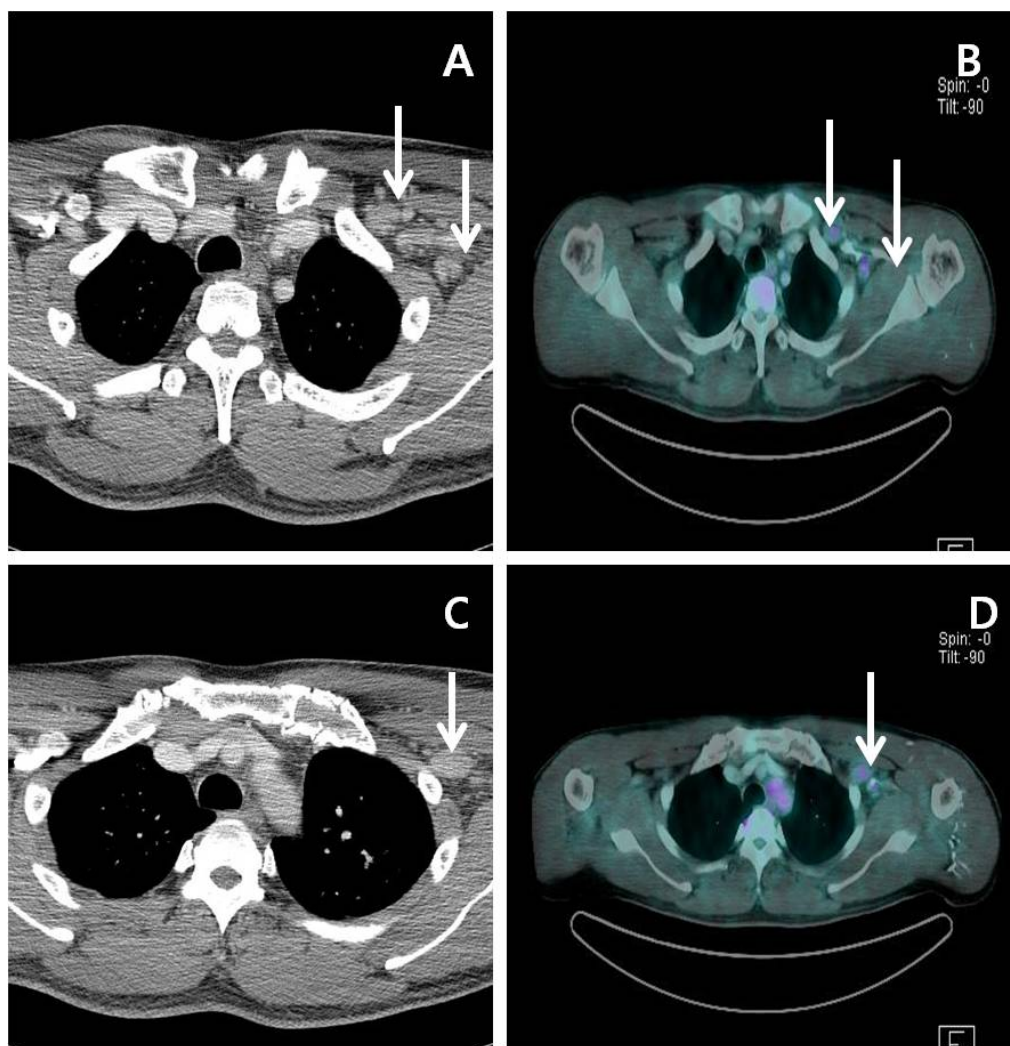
Axillary lymph node metastasis in Neck CT and PET-CT after chemotherapy, RT and surgery. Multiple lymph nodes on left axillary area. The largest was measured at 2.3 cm in diameter with FDG uptake.
